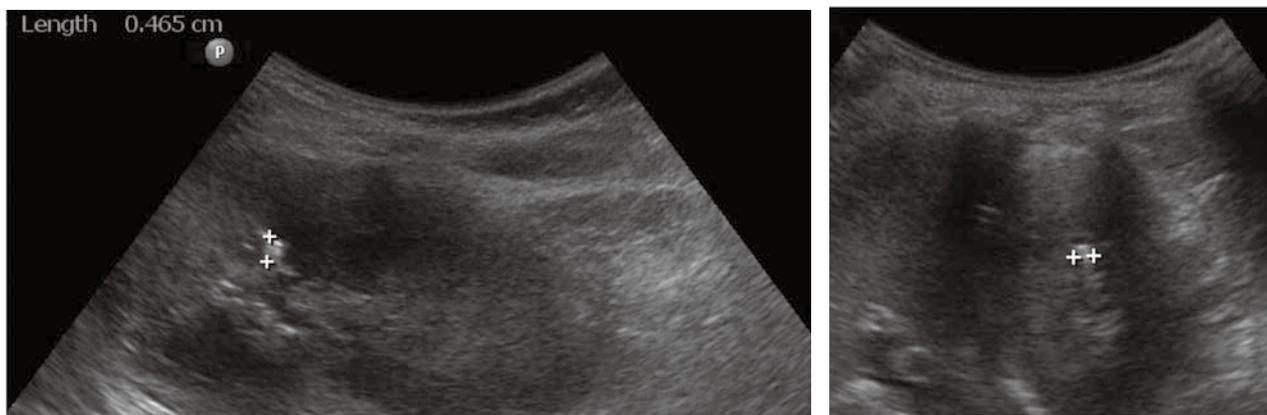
Ultrasonographic image showing a case of renal stone associated with MTMP. Note the echogenic focus (4.7 mm) casting a posterior acoustic shadow.
